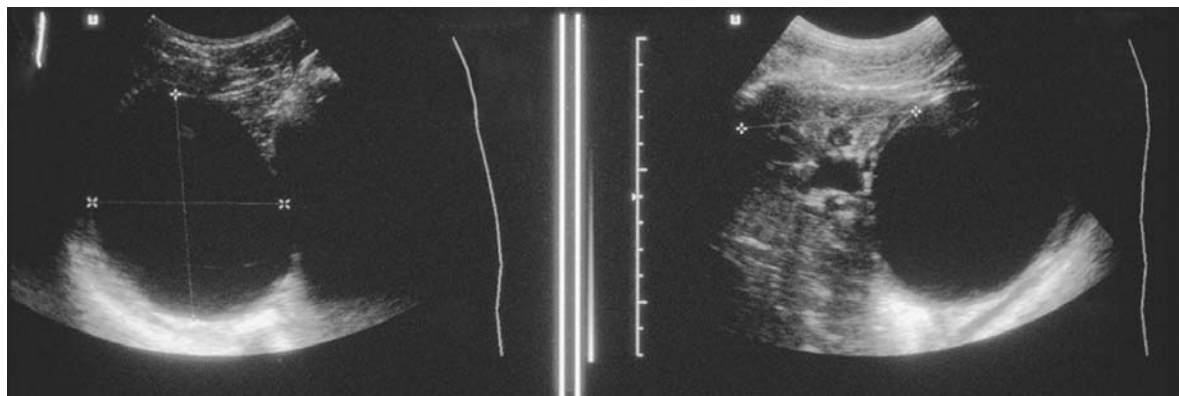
Ultrasound appearances of large simple cyst in the lower pole of the left kidney of a 7-year-old boy presenting with abdominal pain and a palpable mass. The condition was successfully managed by laparoscopic partial excision/deroofting.
